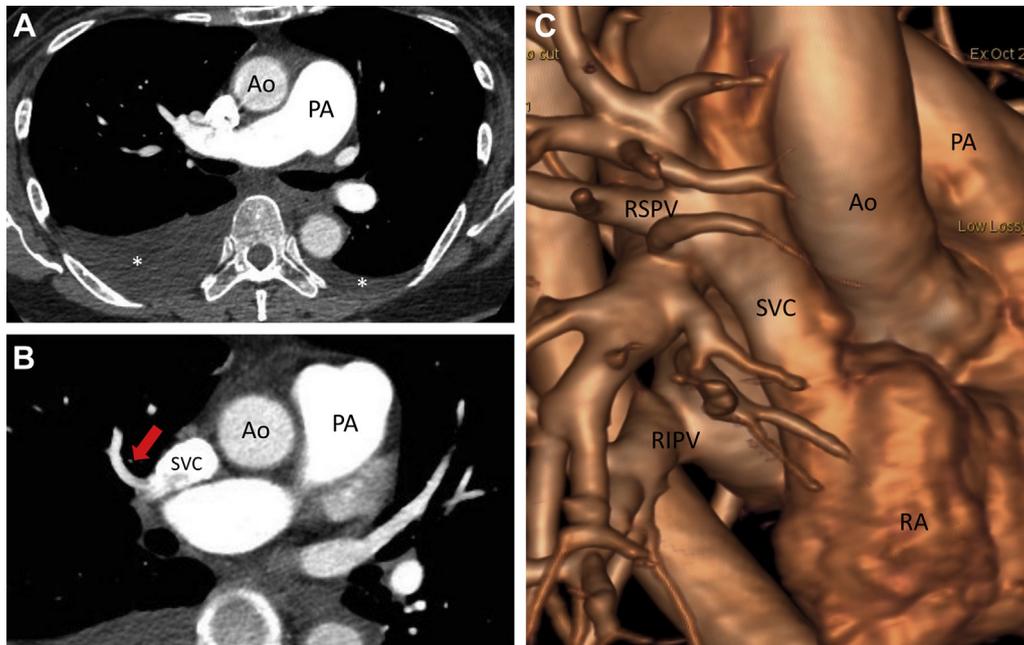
(A) Computed tomography (CT) image showing pleural effusions (white asterisks) and enlargement of the pulmonary artery (PA) compared with the aorta (Ao). (B) CT image showing anomalous connection between right superior pulmonary vein (arrow) and the superior vena cava (SVC). (C) Three-dimensional cardiac magnetic resonance reconstruction, showing the anomalous right superior pulmonary vein (RSPV) draining into the SVC. The right inferior pulmonary vein (RIPV) drains normally into the left atrium.
